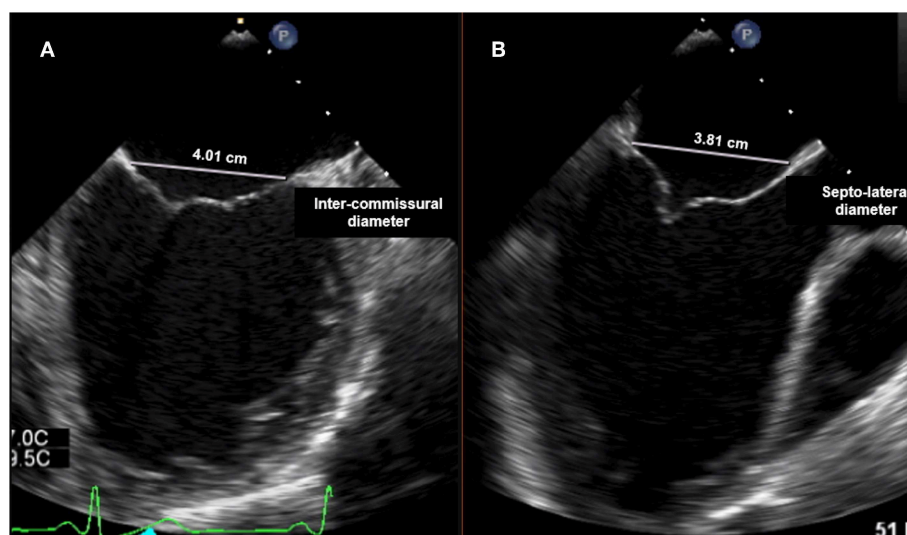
Transesophageal echocardiography (TTE): (A) intercommissural view focused on MV for intercommissural diameter measurement; (B) mid-esophageal Long-axis view (ME LAX View) for septo-lateral (antero-posterior) annulus measurement.
